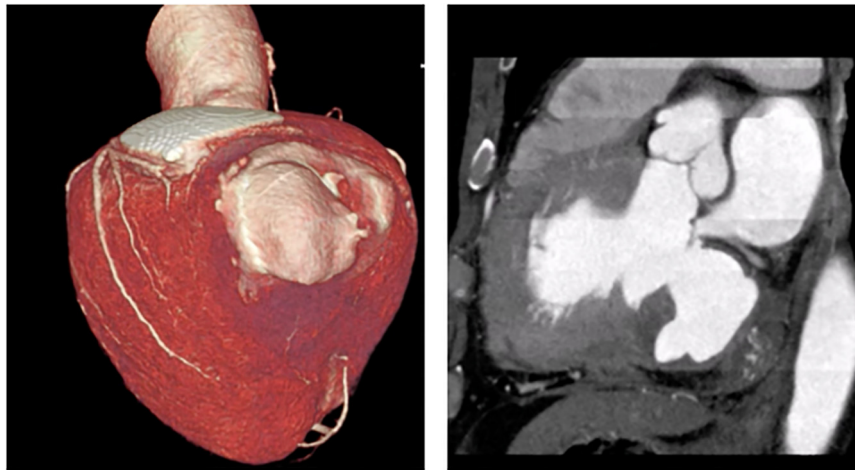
A preoperative contrast enhanced computed tomography image. A pseudoaneurysm was found in the in the posterior wall of the left ventricle.
